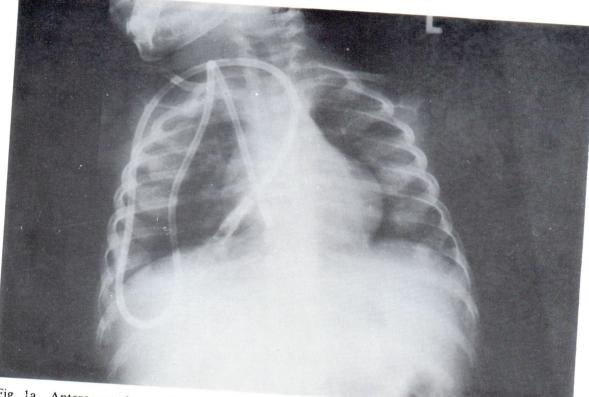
Anteroposterior radiograph of chest showed cupping of the anterior end of ribs characteristic of rickety rosary.
